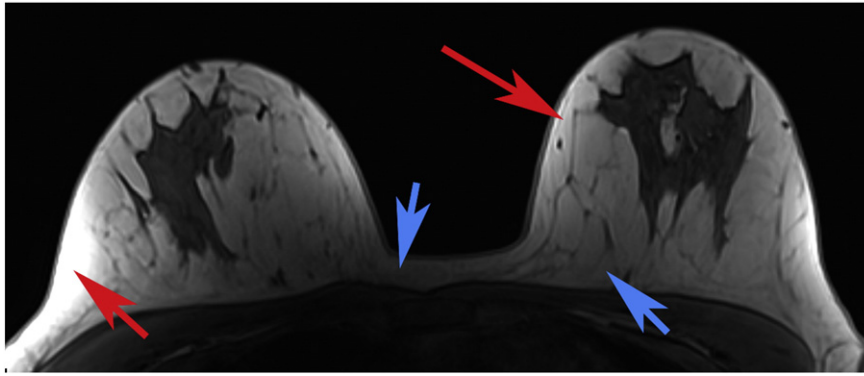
Typical signal non-uniformities in clinical T1 weighted breast magnetic resonance imaging. Breast tissue located adjacent to coil elements (red arrows) shows brighter signal compared with breast tissue located further from coil elements (blue arrows). Such signal non-uniformities can result in misclassification of adipose tissue located distant from the coil as fibroglandular tissue.
